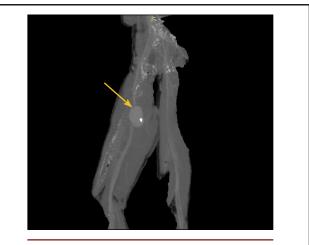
Computed tomography angiogram of a 40-year-old man with a pseudoaneurysm in the right superficial femoral artery secondary to a gunshot injury
